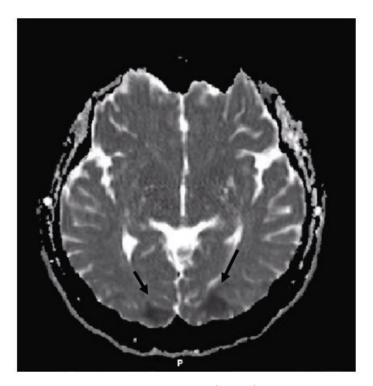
Diffusion Restriction in MRI (arrows)
